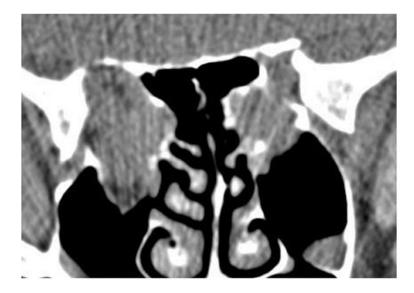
Coronal CT scan post-orbital decompression for DON.
